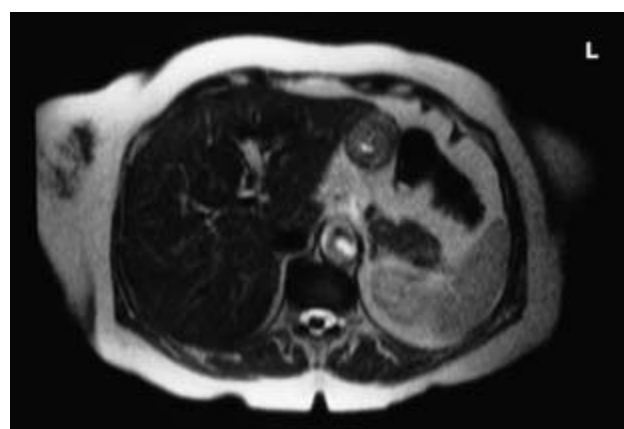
MRI scan (T₂-weighted) showing black low intensity liver due to iron in a patient with haemochromatosis.
